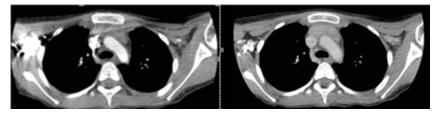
CT of thorax from September 2022.
